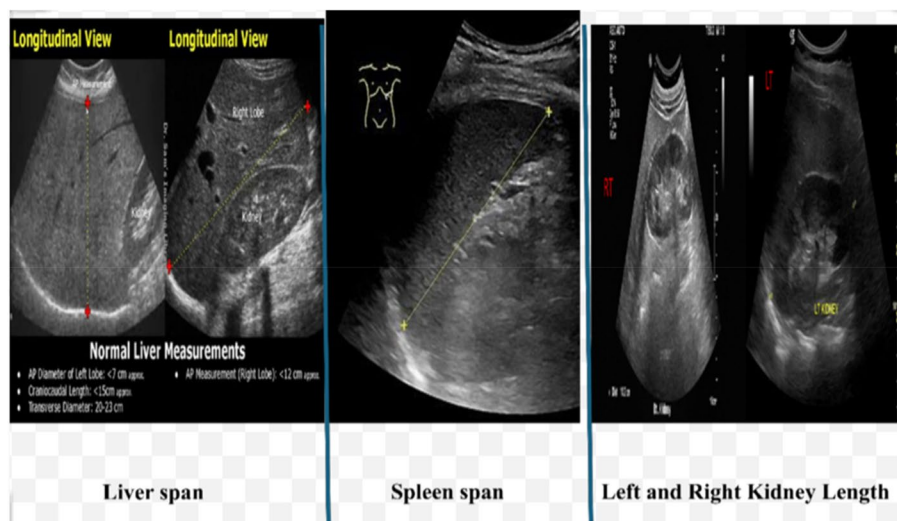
Ultrasound examination of the liver, spleen, and both kidney
